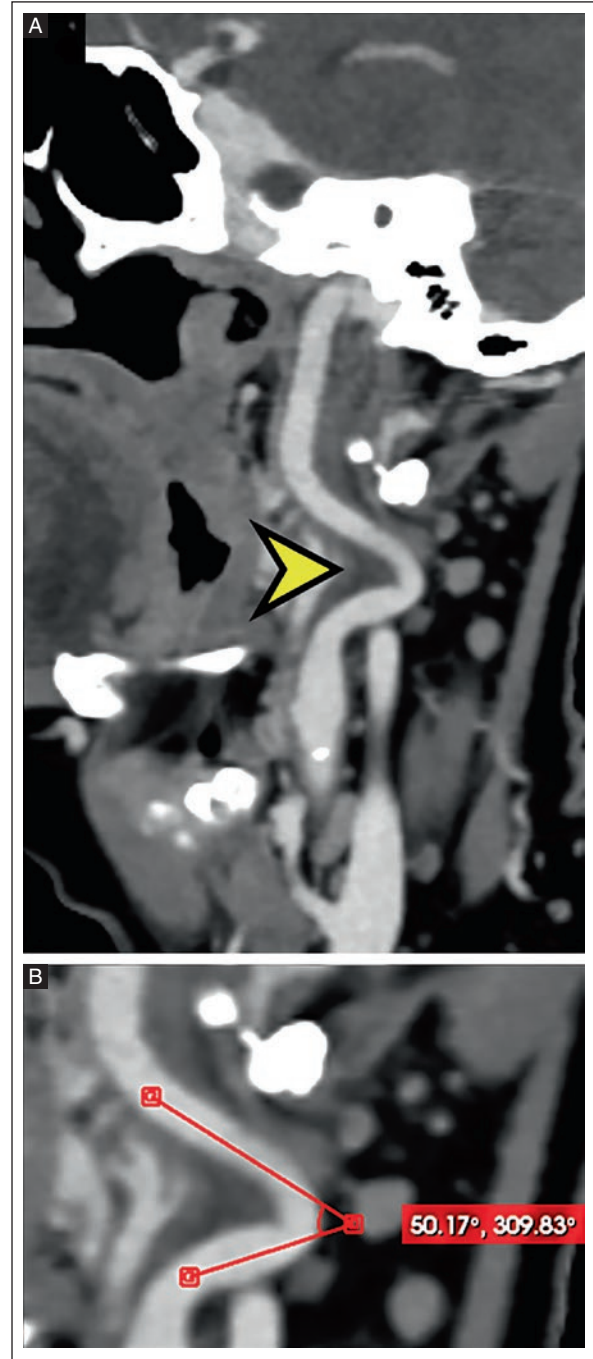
A: reconstruction in the sagittal plane of a neck CTA in a 64-year-old woman with grade II kinking of the EICA, a subtype of dolichoarteriopathy defined by an angulation between 30° and 60° (arrowhead). B: a magnified view with an angle measurement of 50 degrees, classified as a grade II kinking subtype.
